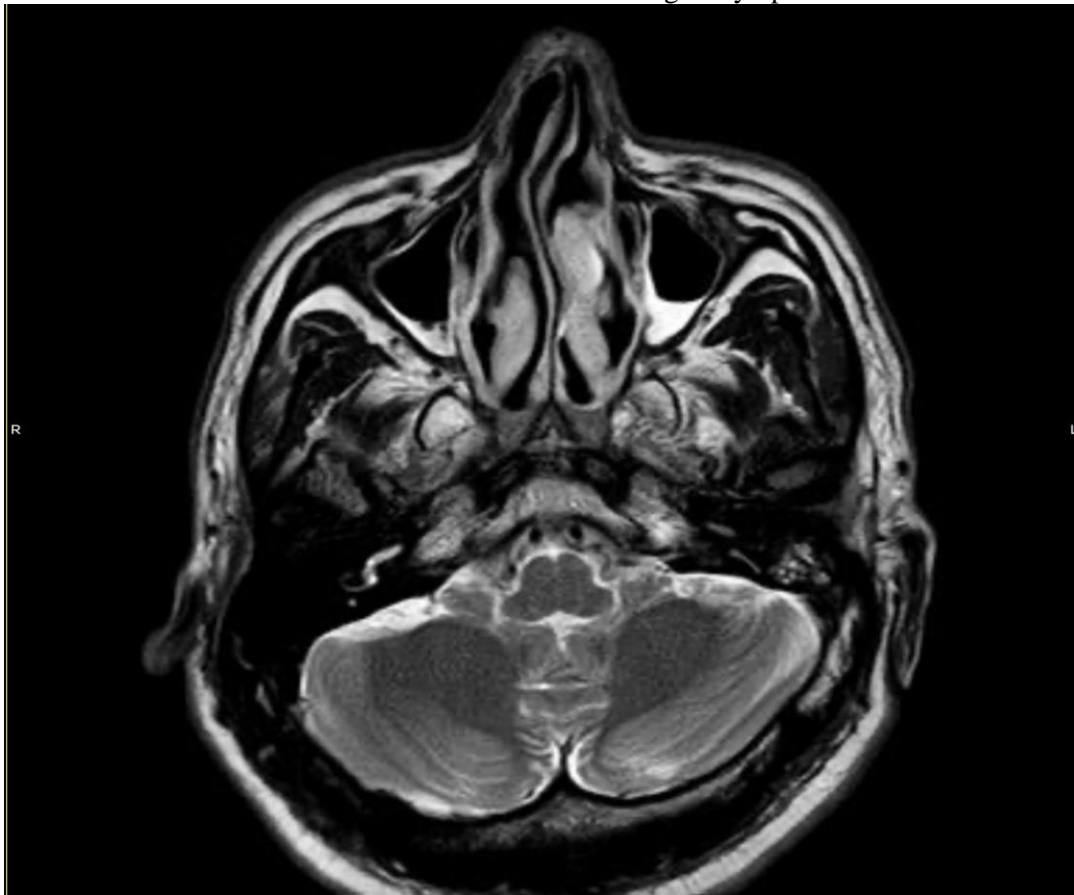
MRI of the Patient Confirming CSF Rhinorrhoea
